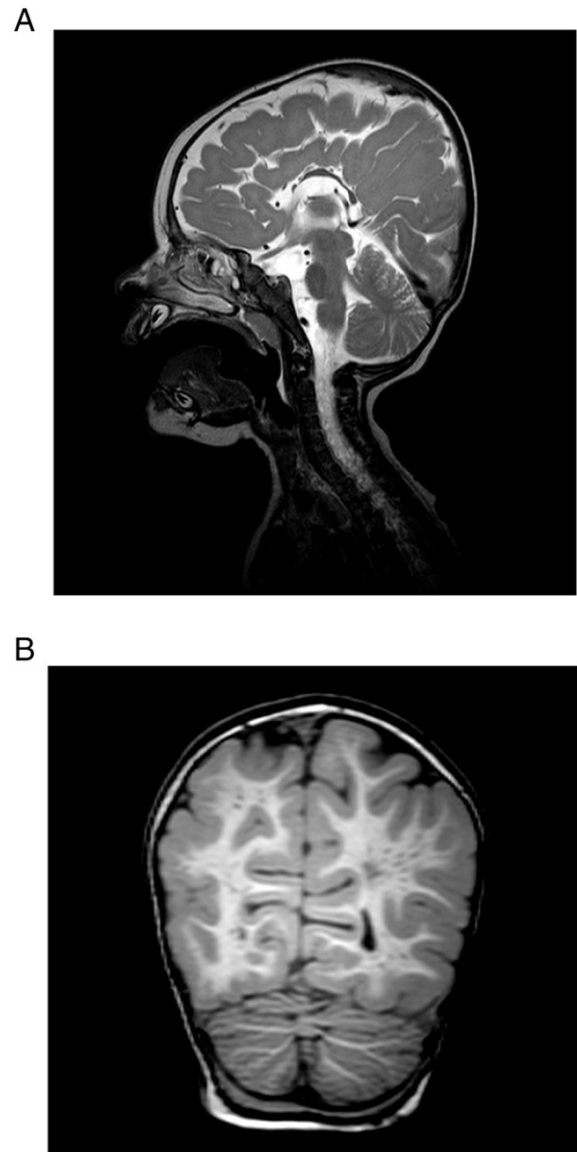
MRI of the patient showing signs of microcephaly, HCC (A) and polymicrogyria affecting the right hemisphere (B).
